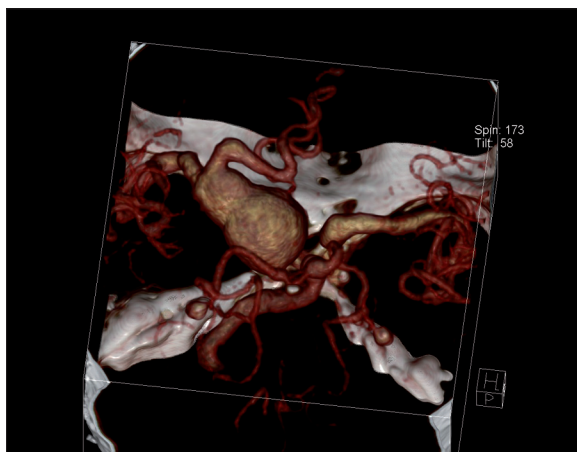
Angio-CT examination, VRT reconstruction; fusiform giant aneurysm of left internal carotid artery occupying its bifurcation.
